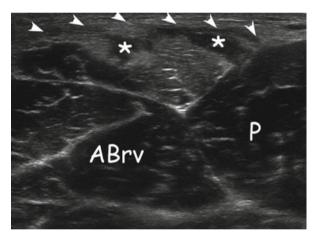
Acute grade II tear (partial tear) of the myotendinous junction of the proximal tendon of the adductor longus. Sonographic transverse scan on the level of the proximal part of the adductor longus. *Arrowheads* indicate localization of the myotendinous injury with hematoma (*asterisks*) and extensive muscle belly edema. *ABrv* adductor brevis muscle, *P* pectineus muscle
